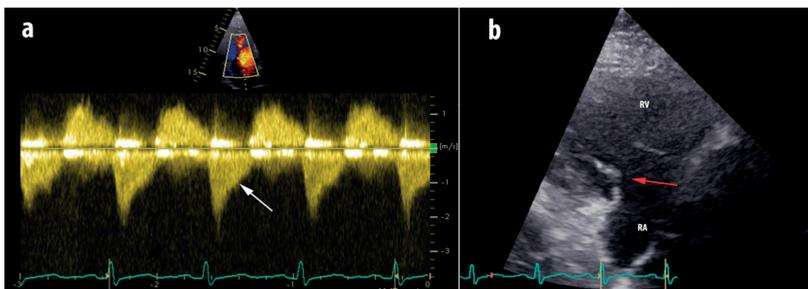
a) Characteristic 'dagger' shaped jet on continuous wave Doppler b) Parasternal view of RV inflow tract showing thickening and retraction of tricuspid leaflets (arrow) during systole. RV right ventricle; RA right atrium
